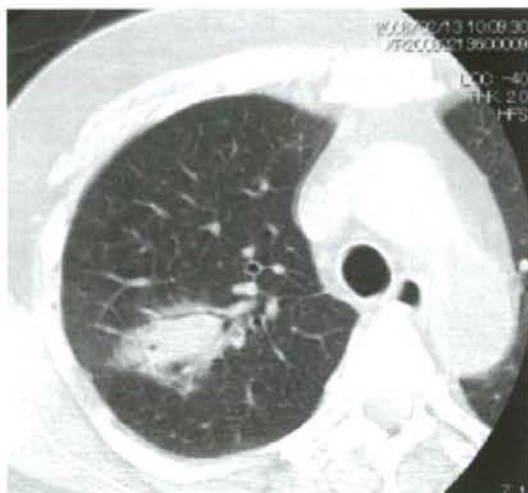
Computed tomography image on day 50 showing consolidation in the right upper lobe, and homogenous amorphous opacification with air bronchograms, but not showing the typical cavitary consolidation of tuberculosis.
